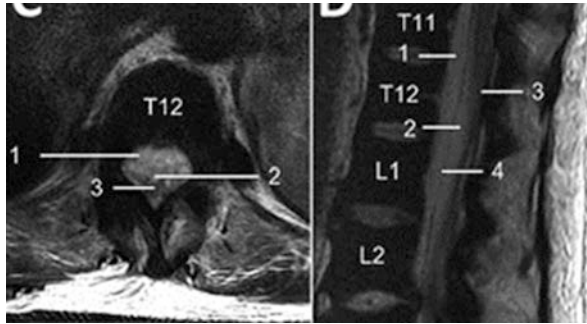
MRI (sagittal and T2-weighted images of thoracic 11 (T11) to Lumbar 2 (L2) vertebra levels) of a patient diagnosed with a methicillin-sensitive *Staphylococcus aureus* infection. There is ventral, 1—epidural and 2—subdural spinal collection with 3—dorsal displacement of conus medullaris. The 4—dura mater can be seen delineating the theca and separating the subdural and epidural spaces. (Image Source—Emerging Infectious Diseases journal—CDC (Jewell et al. 2019)—Copyright Restrictions: NONE; this image is in the public domain and thus free of any copyright restriction)
